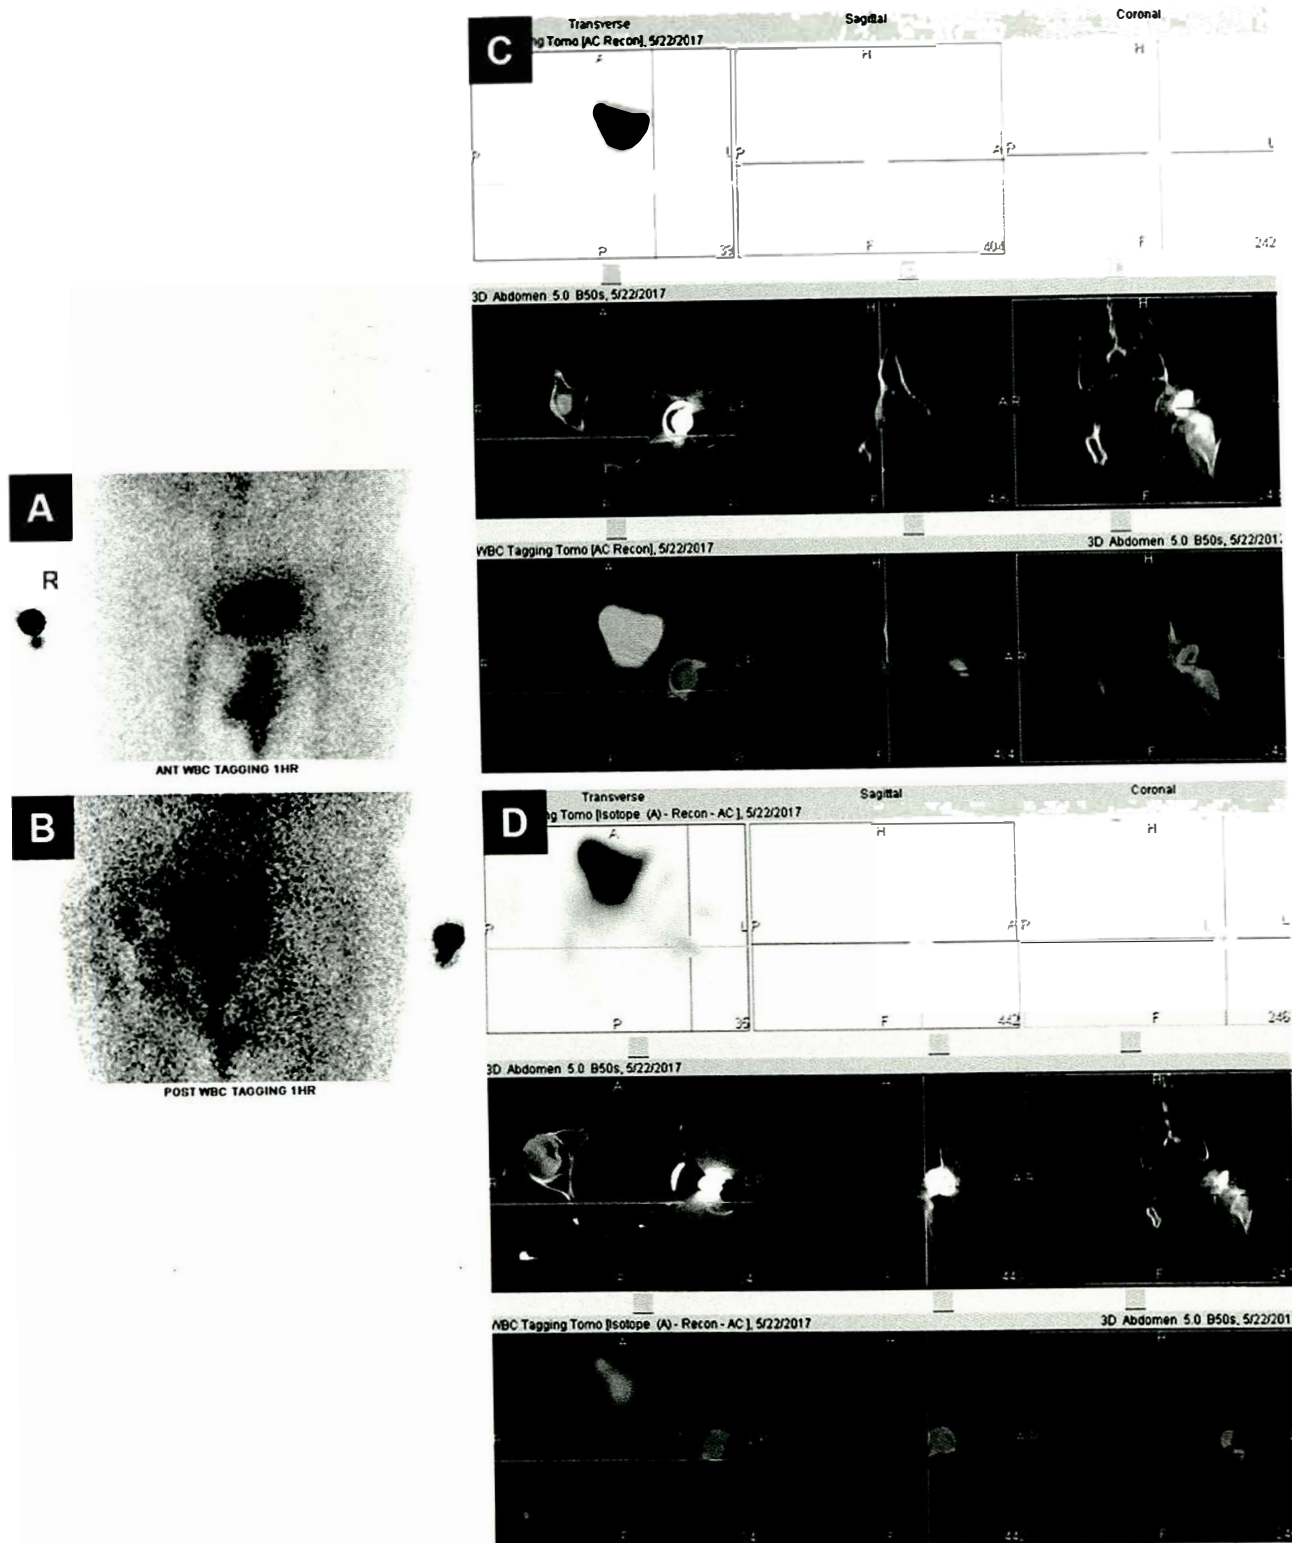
Planar images from the WBC tagging study obtained 1 hour after ^{99m}Tc -WBC injection [A-B] showed increased tracer uptake in the periprosthetic areas of the left hip. On SPECT/CT, this was localized to the left peri-acetabular region [C] and left femoral neck [D].
